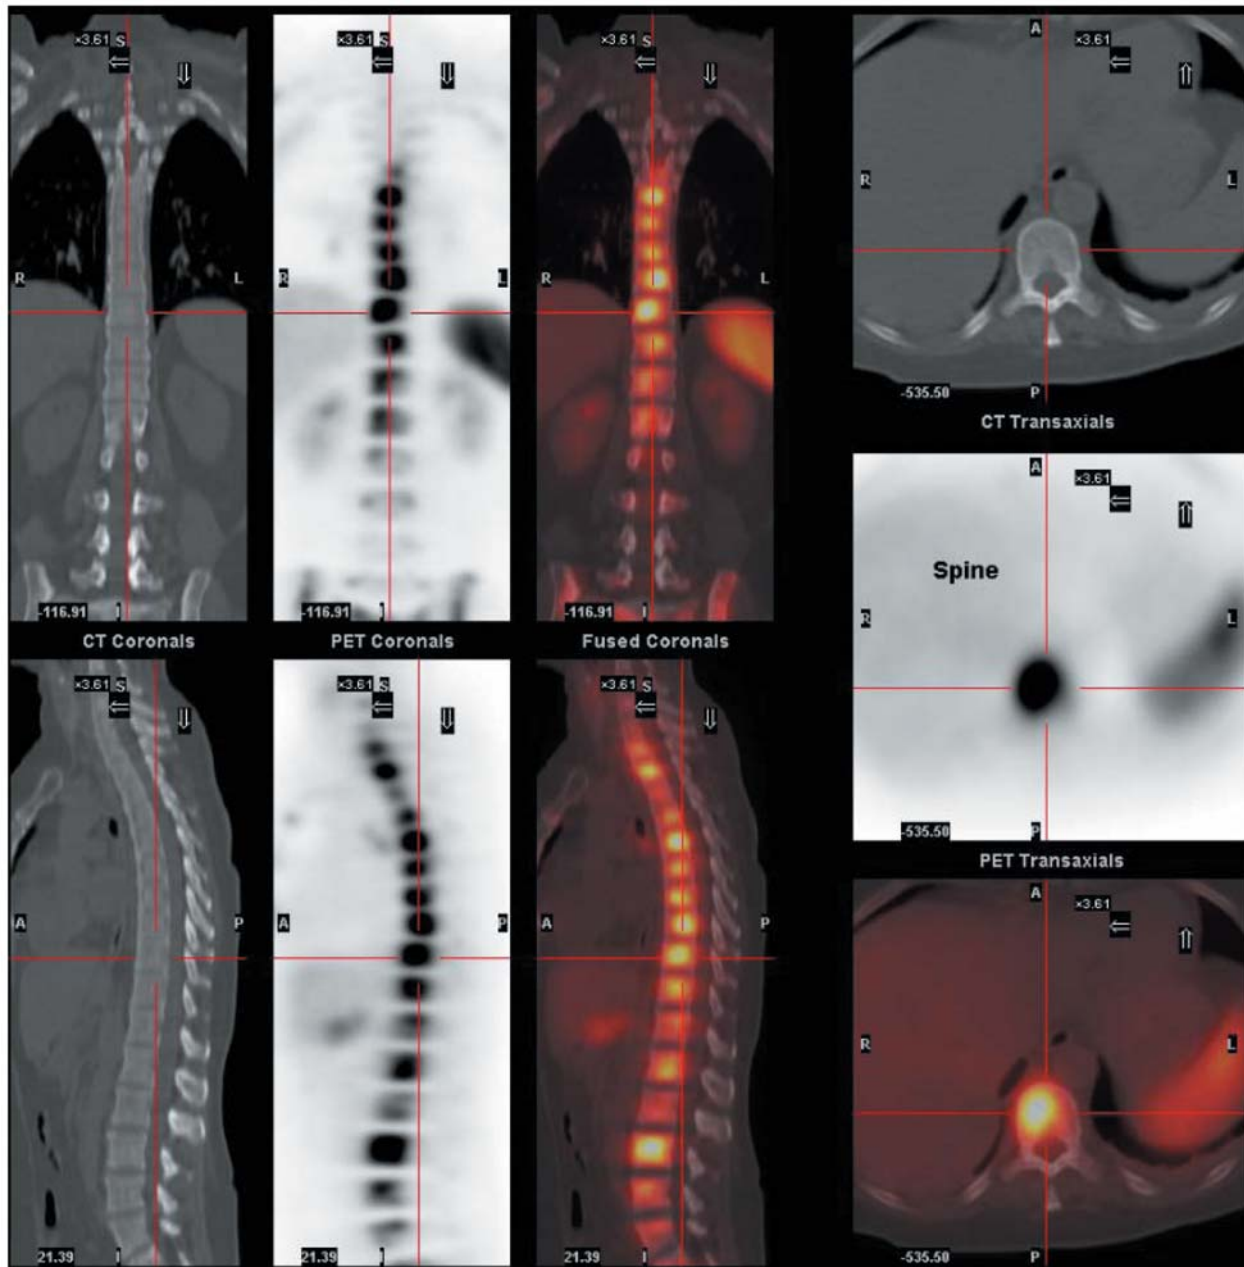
Positron-emission tomography-computed tomography scan showed widespread, intense abnormal focus of fluorodeoxy-glucose uptake in the skeleton.
